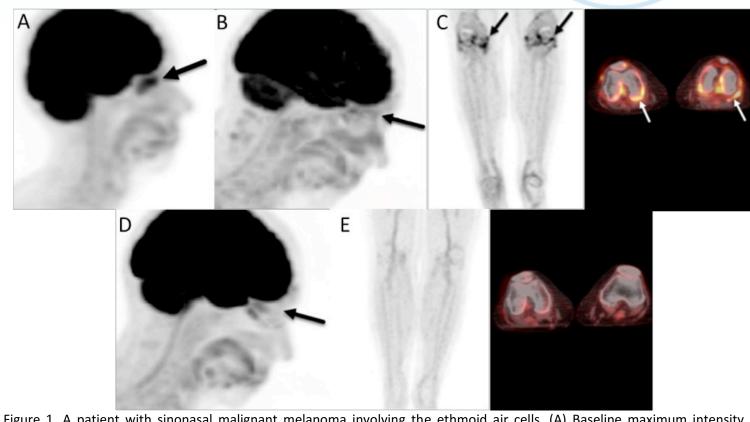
A patient with sinonasal malignant melanoma involving the ethmoid air cells. (A) Baseline maximum intensity projection (MIP) PET image at 1 month before initiation of ICI (ipilimumab and nivolumab) shows avid FDG uptake of the tumor at the ethmoid air cells (arrow). (B) MIP PET image at 7 months after ICI initiation shows resolution of the FDG uptake at the site of the tumor, consistent with complete response. (C) Concurrent MIP PET and corresponding fused PET-CT images 7 months after initiation of ICI show avid radiotracer uptake at the knee joints, suggestive of arthritis. (D) MIP PET image at 10 months after concomitant therapy with IL6R antagonist and nivolumab shows persistent absence of hypermetabolic radiotracer activity at the paranasal sinuses, consistent with complete response. (E) Concurrent MIP PET and corresponding fused PET-CT images show physiologic radiotracer uptake at the knee joints, consistent with resolving arthritis.
